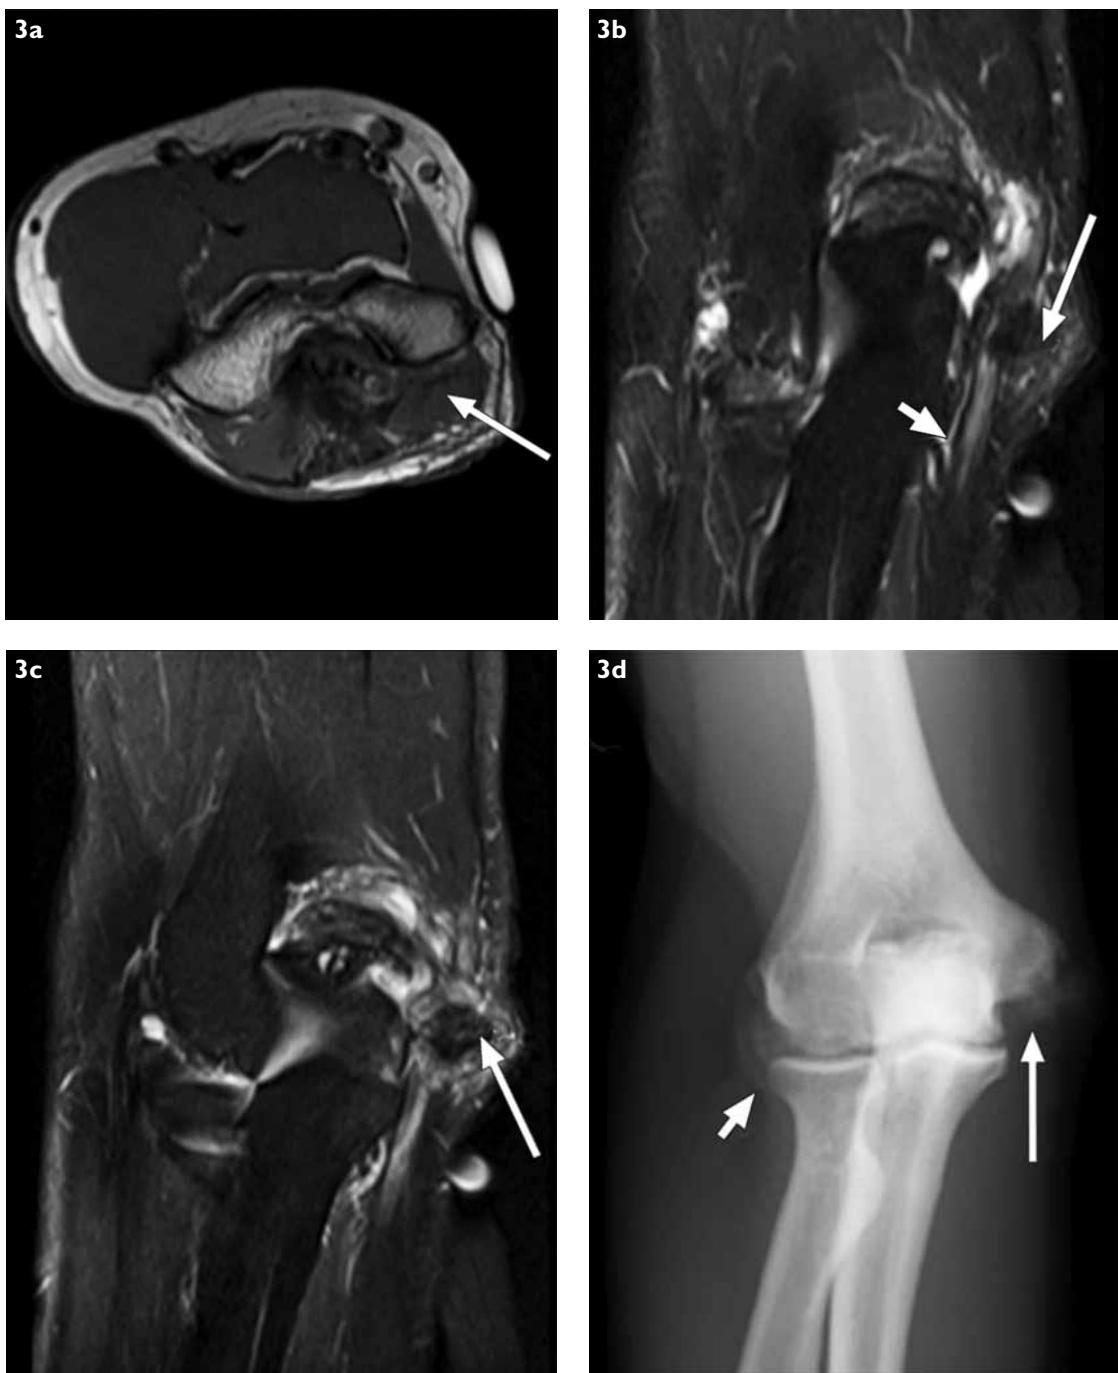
(a) Axial T1-W MR image of the left elbow shows that the ulnar nerve is inseparable from the isointense soft tissue mass (white arrow) in the cubital tunnel. (b) Fat-saturated coronal T2-W MR image of the left elbow shows the ulnar nerve compressed by the tophus (white arrow). Distal to the compression, the ulnar nerve is thickened and oedematous (arrowhead). (c) Post-contrast, fat-saturated coronal T1-W MR image of left elbow shows enhancement of the granulation tissue surrounding the tophus (white arrow), giving rise to a rim-type pattern of enhancement. (d) Frontal radiograph of the left elbow shows erosion of the medial humeral condyle, with associated amorphous periarticular calcification (white arrow), corresponding to the location of the soft-tissue mass seen on the MR images. Calcification of the radiocapitellar joint is also present (arrowhead).
